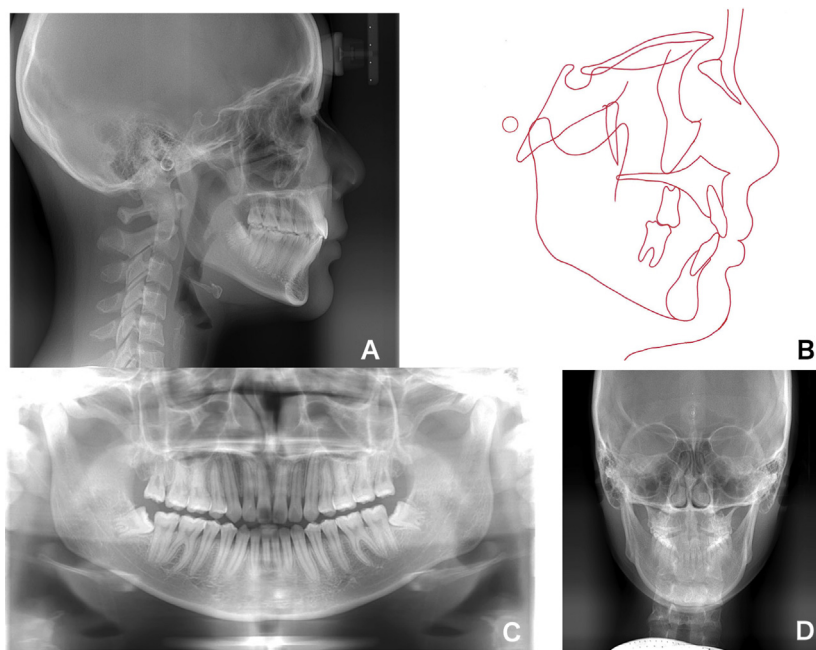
Patient 1: A-D, posttreatment cephalometric radiograph, cephalometric tracing, and panoramic and PA radiographs.
